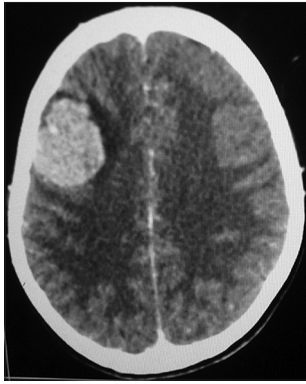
Computed tomography scan showing well defined, extra axial right frontal mass measuring 4 cm × 3 cm × 2.6 cm
